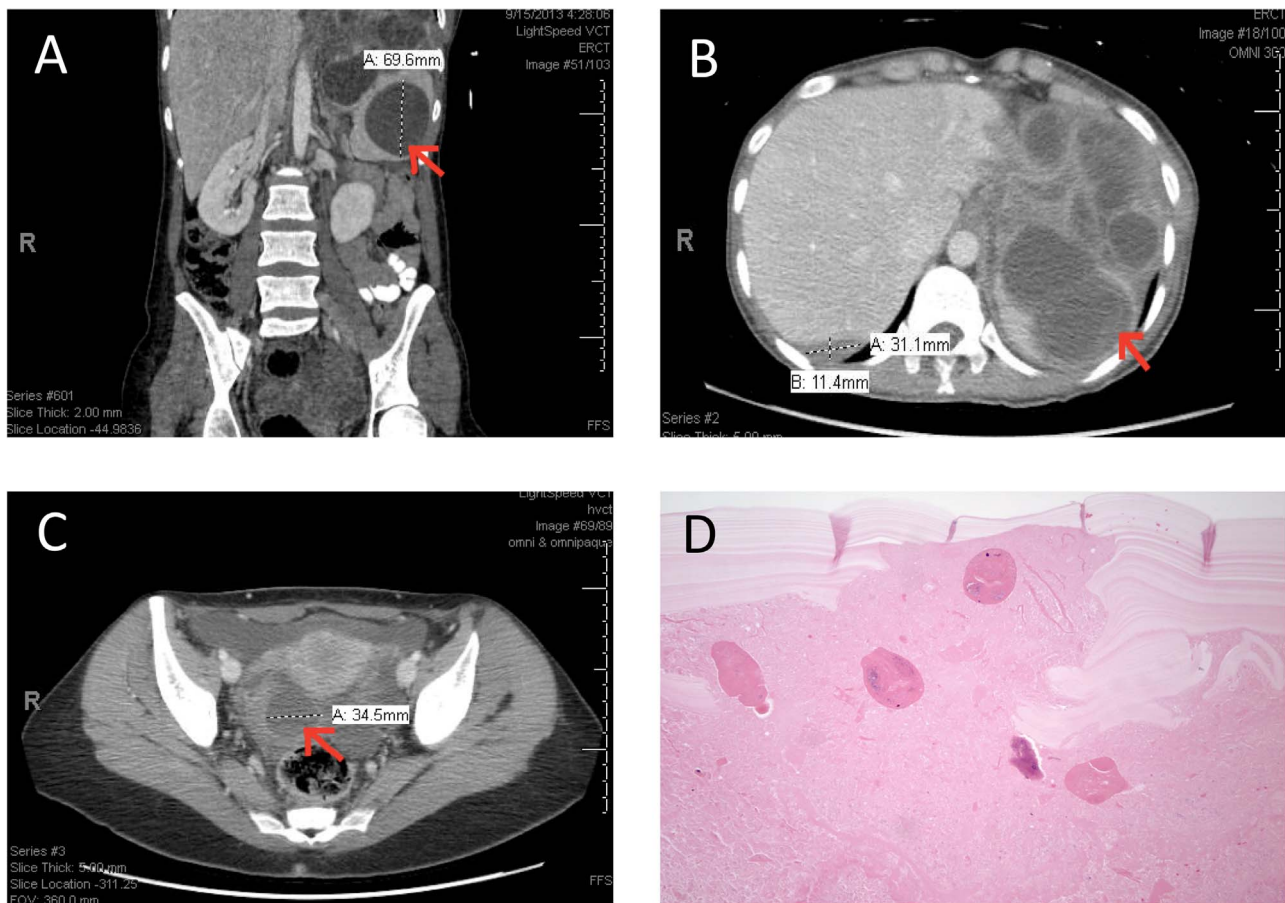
Radiographic and pathologic findings of *Echinococcus granulosus*.
